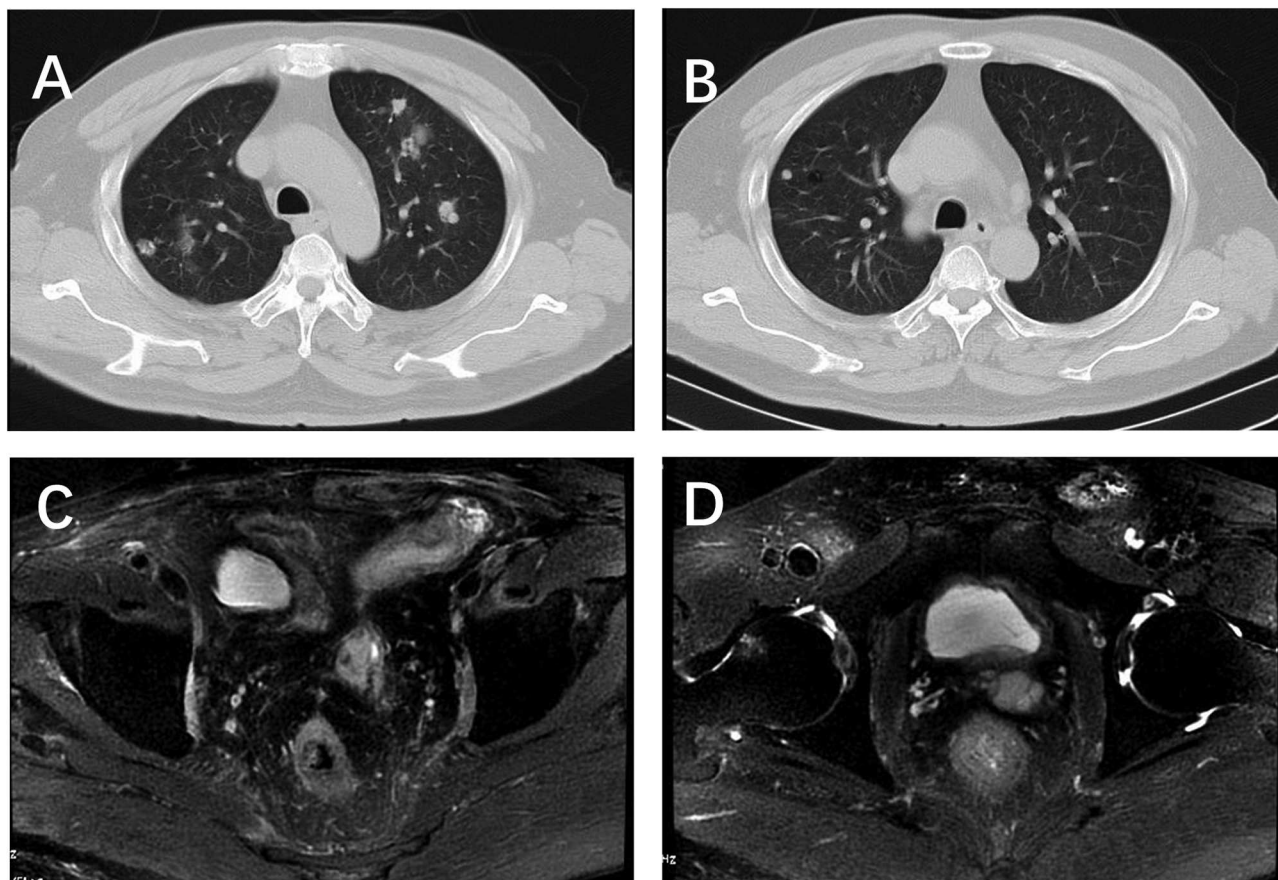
Chest CT and pelvic MRI after 5 cycles etoposide chemotherapy. (A,B) 80% decrease in size of measurable lung nodules; (C,D) no visible recurrence shown on the pelvic MRI.
